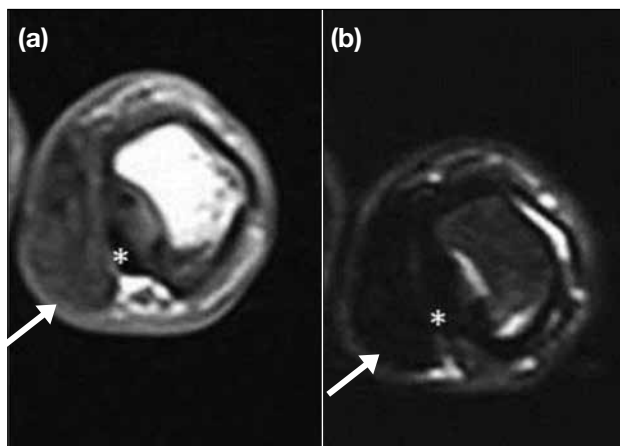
Fibroma of tendon sheath in an 80-year-old man who presented with left thumb mass for one and a half years: (a) T1-weighted axial magnetic resonance image shows an oval-shaped circumscribed mass (arrow) over the palmar aspect of the thumb, at the proximal phalangeal level, partially encasing the flexor tendon (asterisk). It shows T1-isointense signal to muscle with hypointense areas at its centre. (b) T2-weighted axial magnetic resonance image showing homogeneous hypointense signal over the corresponding lesion.
